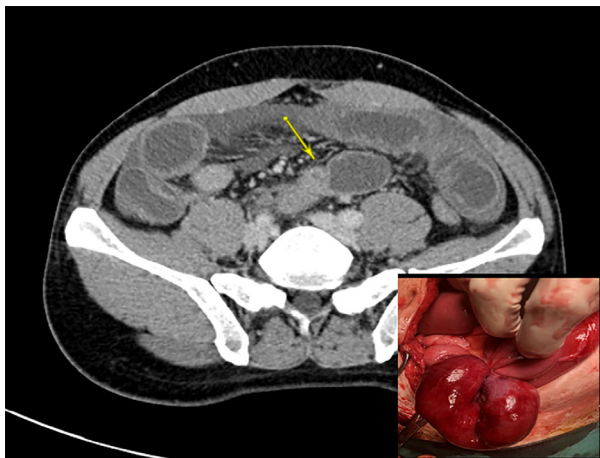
A patient with no relevant medical history showed symptoms of small bowel obstruction. The computed tomography scan shows dilated distal jejunal loop with a transition point suggestive of small bowel obstruction. At laparotomy, a congenital adhesion band from the root of the mesentery to the bowel loop was detected and lysed. Yellow arrow indicates the transition point.
